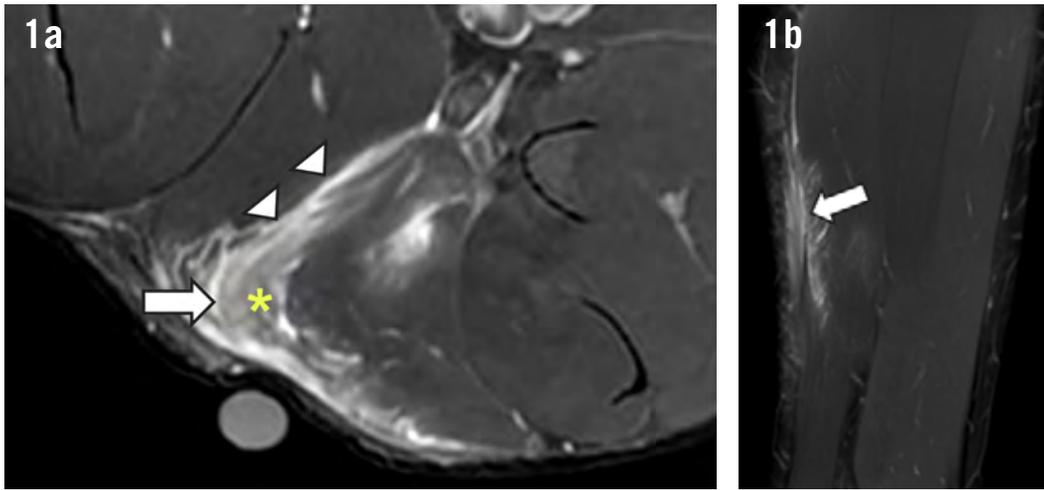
Magnetic resonance imaging of a hamstring injury affecting the distal biceps femoris. Axial (a) and coronal (b) T2 weighted images with fat saturation. There is edema (asterisk) and architectural disruption of the muscle fibers and intramuscular tendon (arrows) in the distal myotendinous junction of the long head of the biceps femoris, also involving the T-junction in the interface with the short head (arrowheads). Coronal images are useful to determine the longitudinal extent of the injury and loss of tension.
